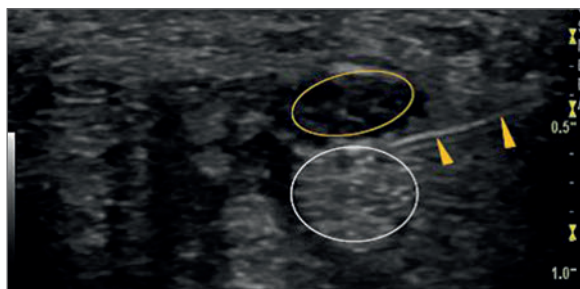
Transverse ultrasound image of the carpal tunnel. The median nerve appears as a low echo oval-shaped foci (yellow oval). The tendons of flexor digitorum superficialis (white oval) may be seen deep to the median nerve. A needle may be seen immediately between the two (yellow arrowheads).
